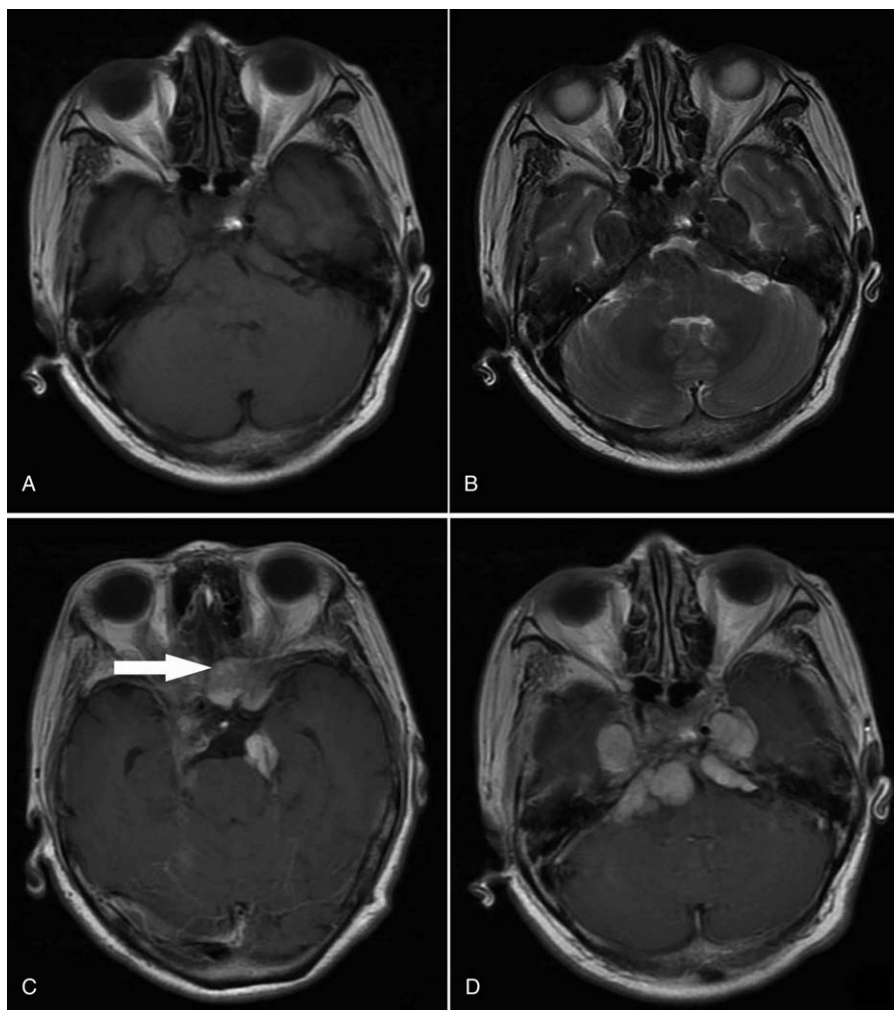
Contrast-enhanced Magnetic resonance imaging (MRI) of the brain showed multiple well-defined, homogenous mass which closely related to the dura mater in the bilateral parasellar and petroclival regions range from the basement of anterior to posterior cranial fossa (A–D). The lesions were isointense on T1-weighted images (A), hypointense on T2-weighted images (B), and showed homogeneous enhancement following the intravenous administration of gadolinium (C–D). The left optic nerve is compressed by the mass in the left basement of anterior cranial fossa (arrow).
